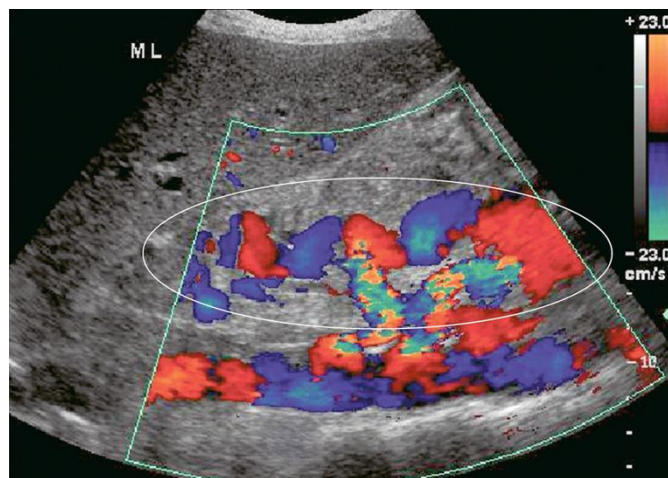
Longitudinal colour Doppler image in the midline of a patient with portal hypertension. A large tortuous left gastric varix is seen coursing from the region of the coeliac axis towards the gastro-oesophageal junction. Whereas short gastric varices tend to be a plexus of small vessels, the left gastric varix is typically a single large tortuous vessel. (Myron A. Pozniak et al 2014. 161)
